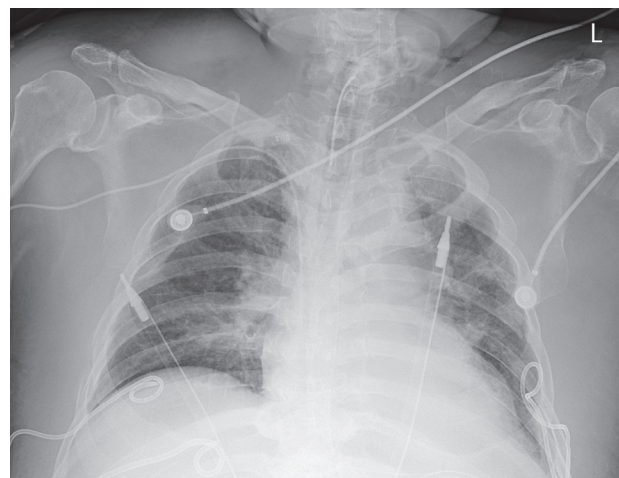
Atelectasis in the left lung disappeared on the follow-up radiography following fiberoptic bronchoscopic toilet.
